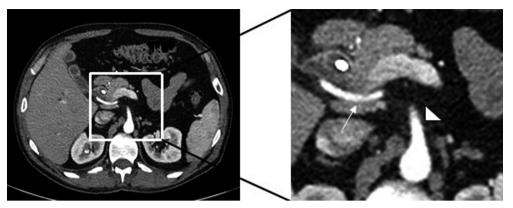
Preoperative CT scan of patient showed a right hepatic artery (arrow) arising from the superior mesenteric artery (arrowhead) and passing in close contact with the tumor. CT, computed tomography.
